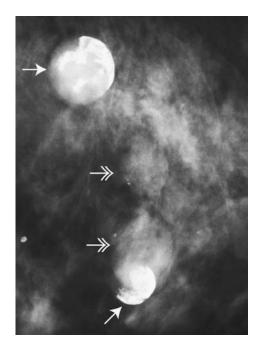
Cysts. Coarse calcifications developing on cyst walls (*arrows*). Additional cysts (*double headed arrows*) with no associated calcifications are present (diagnostic ultrasound not shown).
